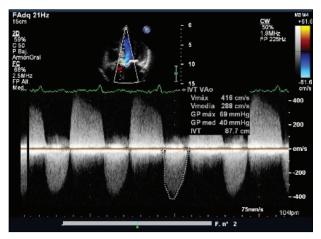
Echocardiogram before implantation.
